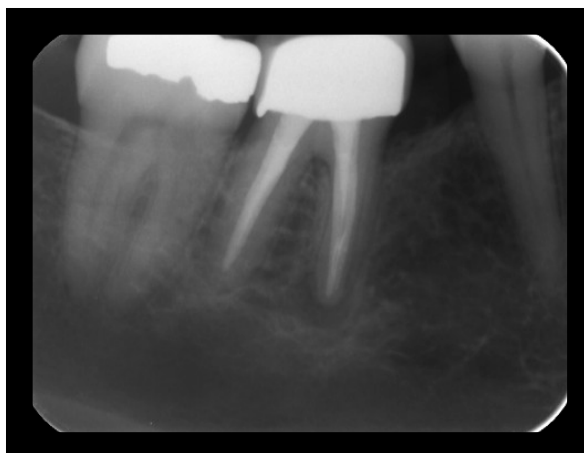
Follow up radiograph
